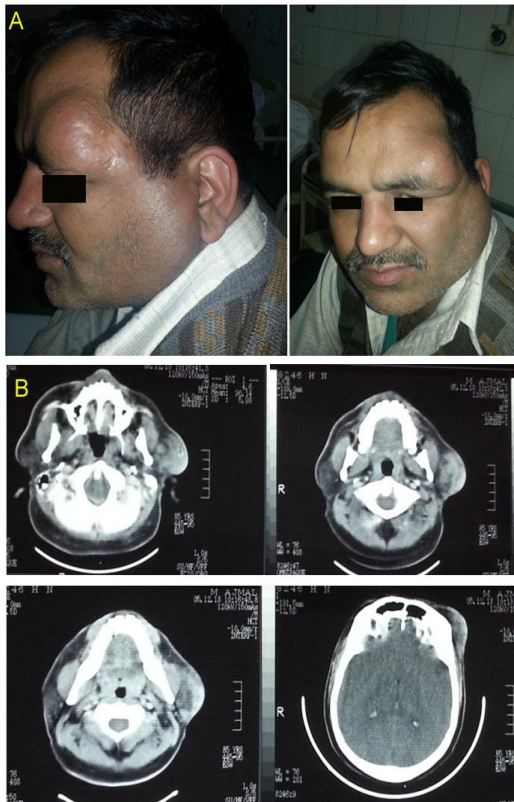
A, Patient presented with recurrent swelling of the left frontal and parotid region, firm in consistency with preserved facial nerve function. B, CT Scan (axial sections taken through head and neck region) The lumps have hyper-dense irregular signals only involving superficial part of parotid gland and sparing deeper portion (*Middle & lower panel*). Hyperdense lesion is also apparent in frontal scalp (*lower panel*).
